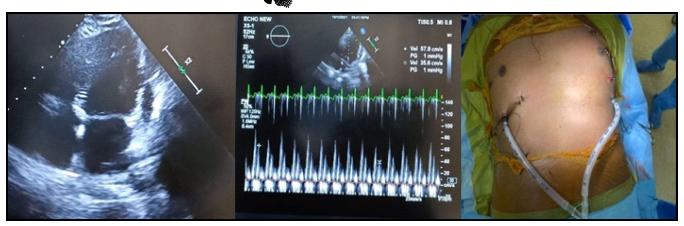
Echocardiography Showing Pericardial & Pleural Effusion with respiratory variation and catheterization of patient
